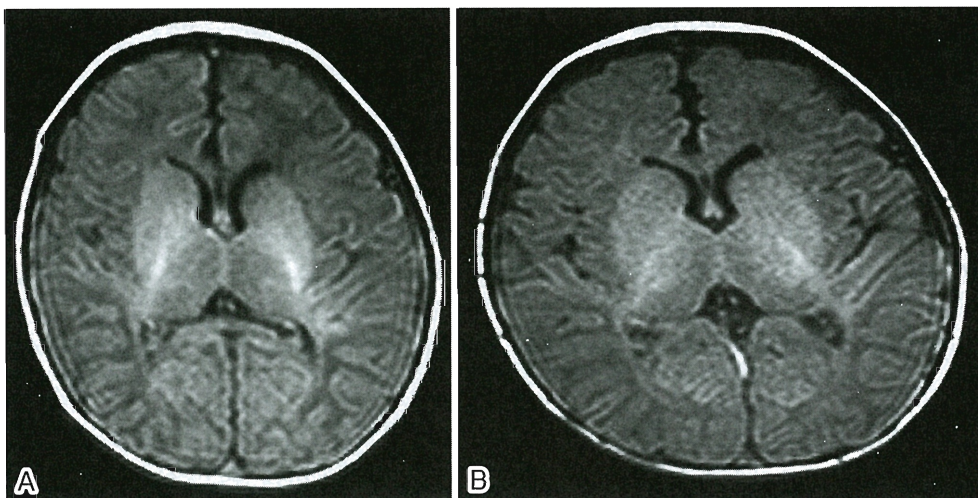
MR images of Patient 7
